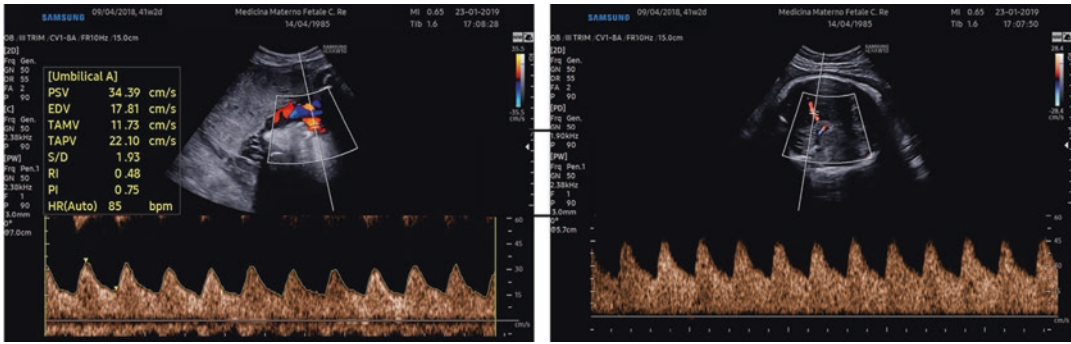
Doppler velocity waveforms in a late FGR. Umbilical artery PI is normal (left panel) while middle cerebral artery PI is reduced (right panel)
